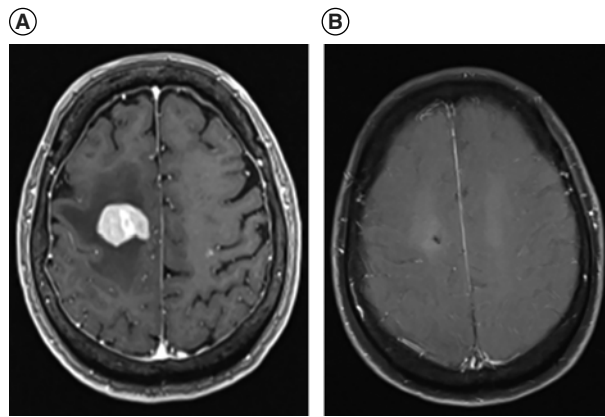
Brain MRIs prior to and after high dose-methotrexate treatment. (A) Brain MRI prior to biopsy showed homogenous enhancing masses on post contrast T1 image. (B) Brain MRI showed resolution of lymphoma lesions on post-contrast T1 image after induction high dose-methotrexate treatment.
